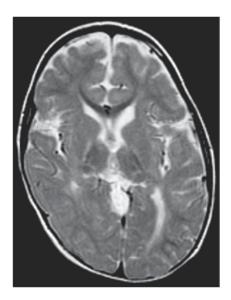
MRI of the brain. This T_2 -weighted image demonstrates abnormal signal intensity in the periventricular white matter and globus pallidus bilaterally.
